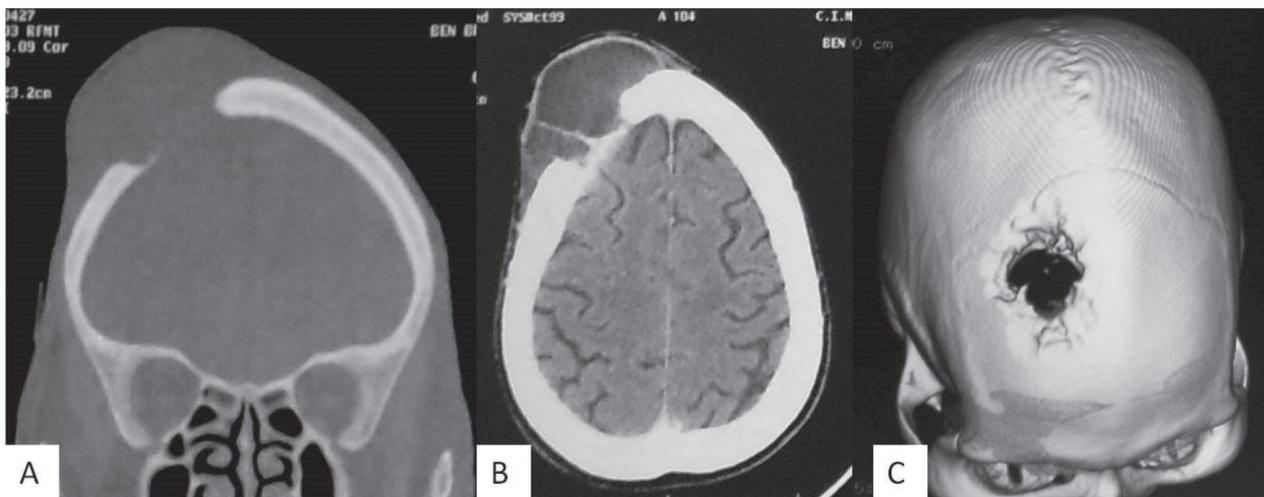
Preoperative cerebral CT scan: (A) bone (B) cerebral and (C) 3D reconstruction; a cystic multilobulated subcutaneous mass is present in the right frontal region with vault osteolysis.
